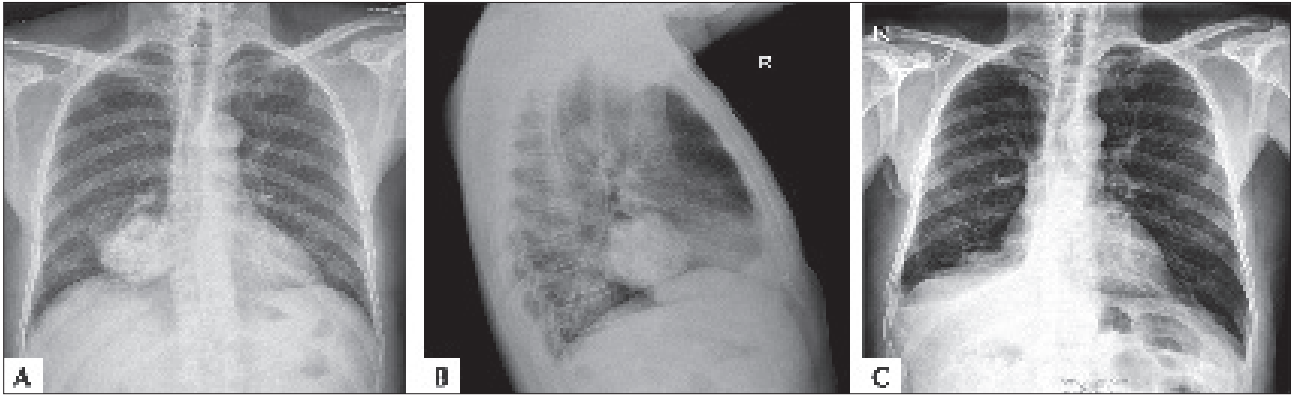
(A) Pre-operative PA chest radiography of the patient, (B) Pre-operative lateral chest graphy of the patient, (C) Post-operative PA chest radiography of the patient.
